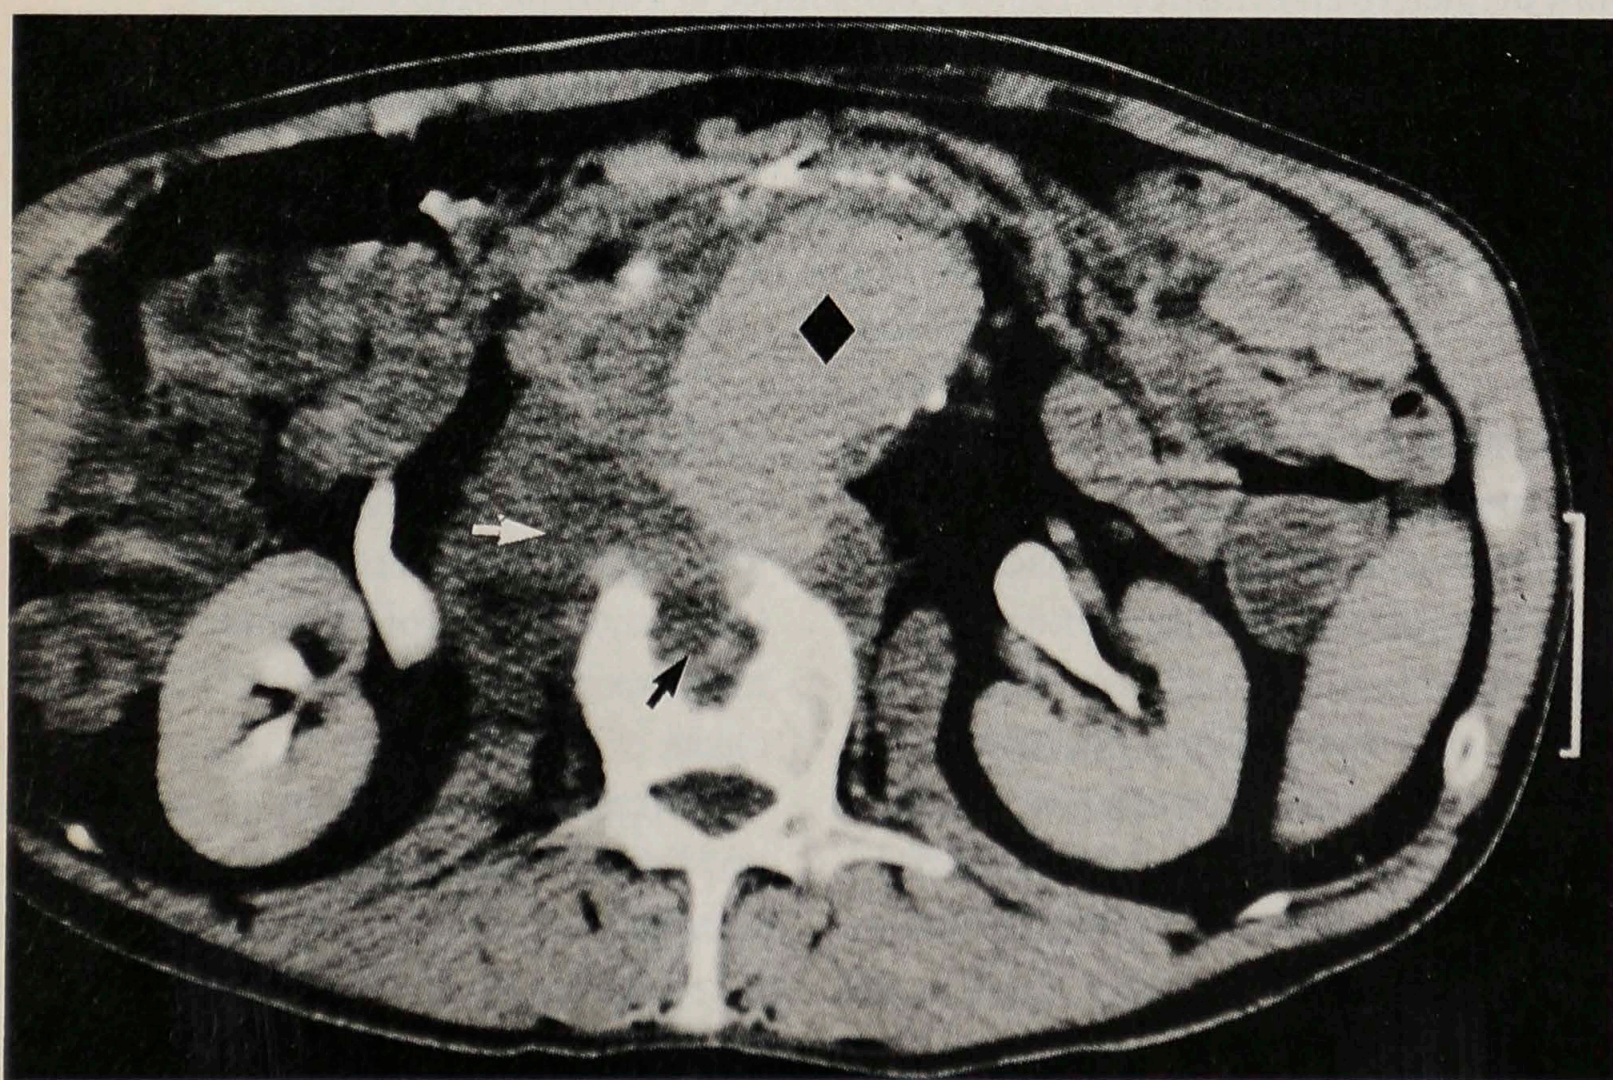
Case 1. (Left) Computed tomography (CT) scan demonstrates ruptured abdominal aortic aneurysm (AAA) (diamond), right-sided retroperitoneal hematoma (white arrow) and vertebral body erosion (black arrow). (Right) Intraoperative view of opened aneurysm demonstrates defect in posterior wall (white arrows) with erosion into underlying vertebral body and disc. Left renal vein is seen at top (diamond).
